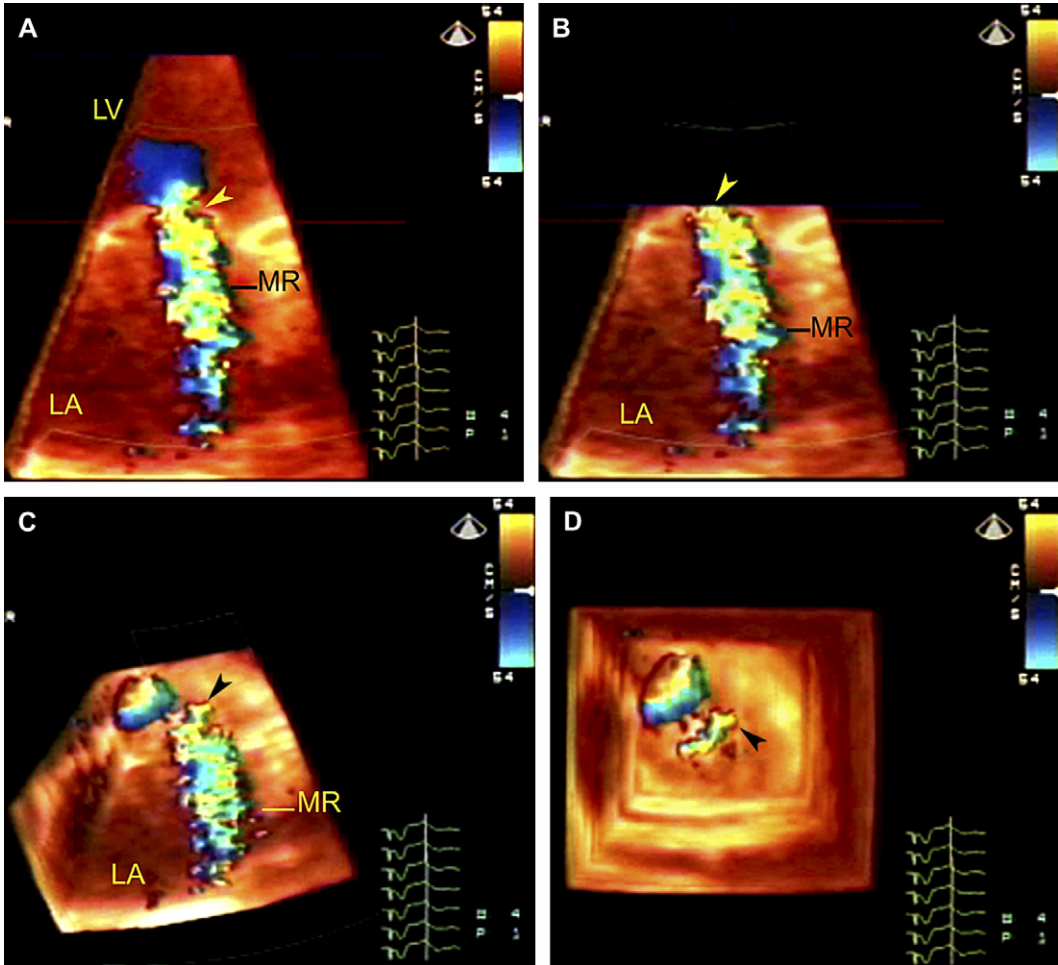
Live 3D color Doppler transthoracic echocardiographic technique for assessment of vena contracta area. 3D color Doppler data set showing mitral regurgitation (MR, *A*) is cropped from top to the level of the vena contracta (*arrowhead*, *B*) and tilted to view it en face (*C*, *D*). The vena contracta then is planimetered by copying onto a videotape. Abbreviations: LA, left atrium; LV, left ventricle. (Reproduced from Khanna D, Vengala S, Miller AP, et al. Quantification of mitral regurgitation by live 3D transthoracic echocardiographic measurements of vena contracta area. *Echocardiography* 2004;21:737–43; with permission.)
